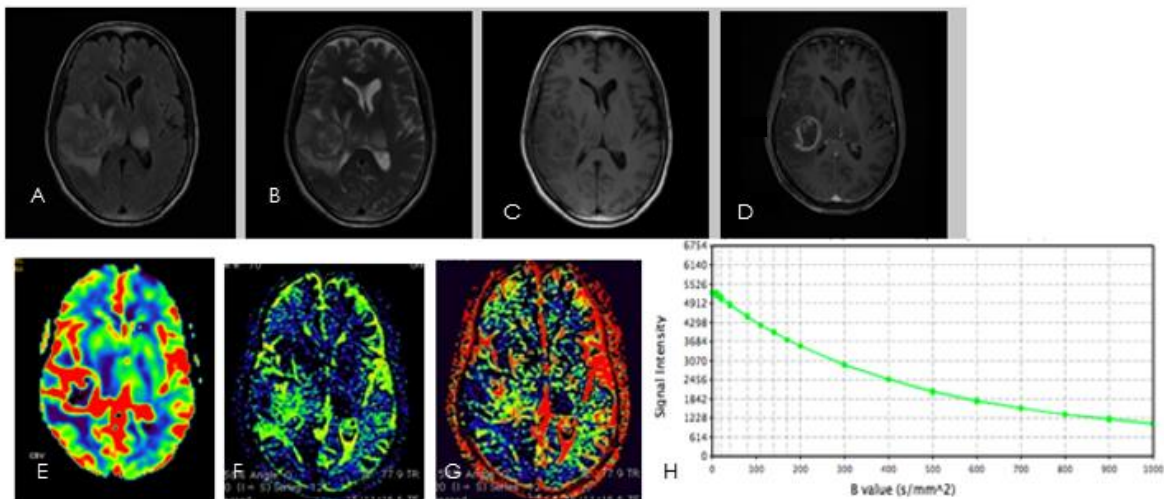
A-C: T2 FLAIR, T2WI, T1WI, D: Post contrast BRAVO, E: RCBV Map of DSC Perfusion, F-G: D^* and f Map of IVIM Imaging, H: Logarithmic plot of signal intensity decay as function of b value.
